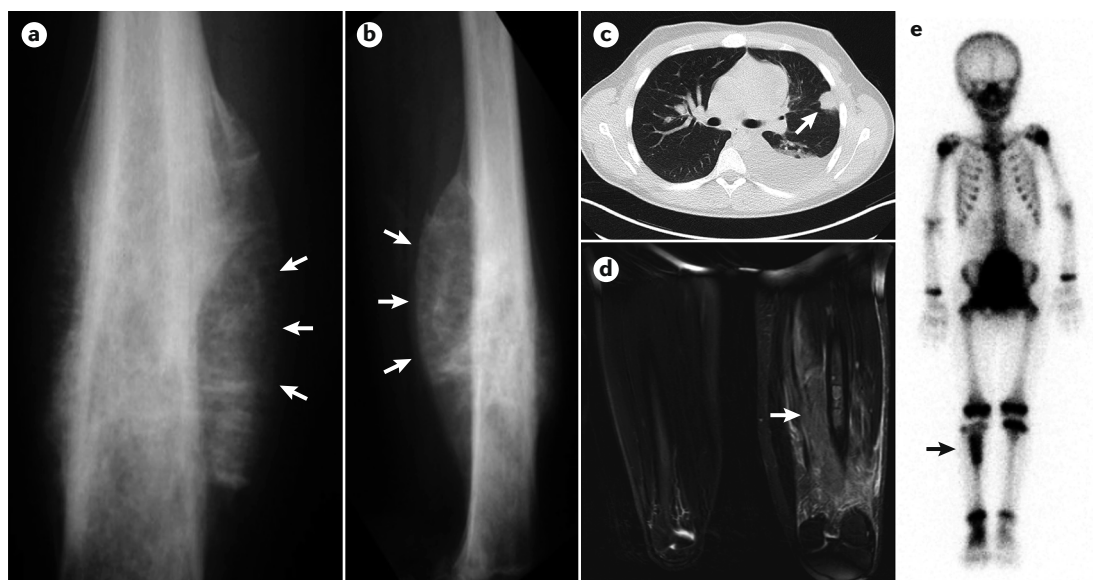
Radiological presentation of Ewing sarcoma. Anteroposterior (panel a) and lateral (panel b) X-ray images showing an osteolytic lesion of a Ewing sarcoma and involvement of the periosteal soft tissue (arrows) in the right femur of a 14-year-old boy. CT scan of the lungs showing a pulmonary metastasis (arrow) in a 19-year-old male patient (panel c). MRI scan (T2-weighted) showing the primary tumour in the right femur with accompanying soft-tissue oedema (arrow) of the patient shown in panel a (panel d). Bone scintigraphy of a 6-year-old male patient highlighting a Ewing sarcoma tumour mass comprising his right tibia (arrow; panel e).
